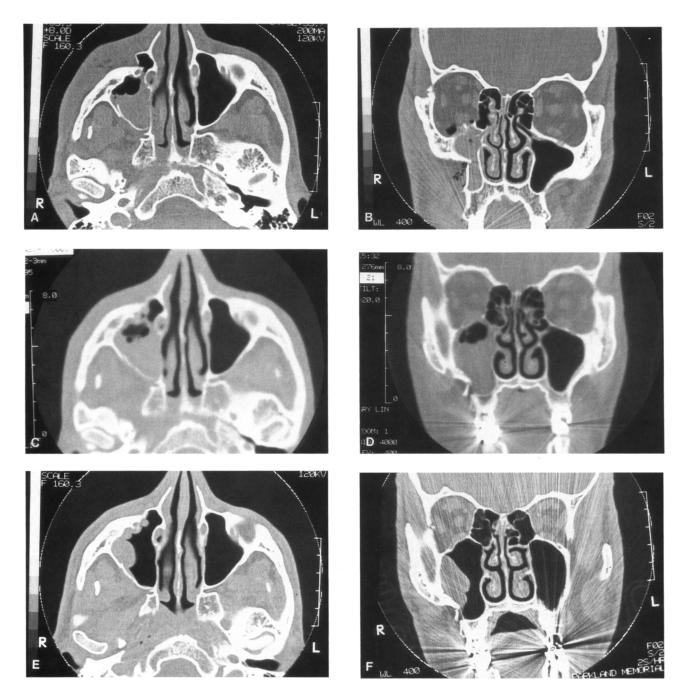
CT scans of patient treated by reduction without any means of fixation. Preoperative axial (A) and coronal (B) scans show displacement. Immediate postoperative axial (C) and coronal (D) scans showing satisfactory reduction (within 2 mm). Axial (E) and coronal (F) scans taken 6 weeks after reduction showing no postsurgical displacement.
